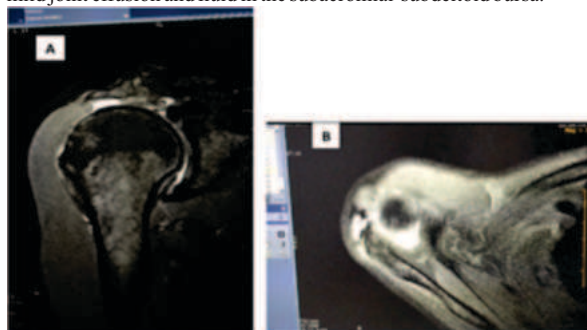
A - Coronal Proton density-fat saturated MRI image showing complete 3.6 cm (C3) of supraspinatus (SST) with grade 1 (Patte classification) retraction of tendon with joint effusion. B - Axial Proton density-fat saturated MRI image showing "U - shape" pattern of tear involving SST.
